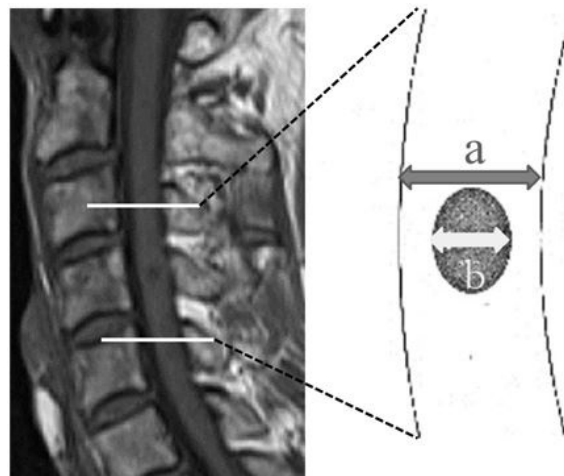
T1-weighted image. Black arrow (a): Cervical spinal cord transverse diameter. White arrow (b): T1 low transverse diameter. T1-low diameter ratio was b/a (%).
